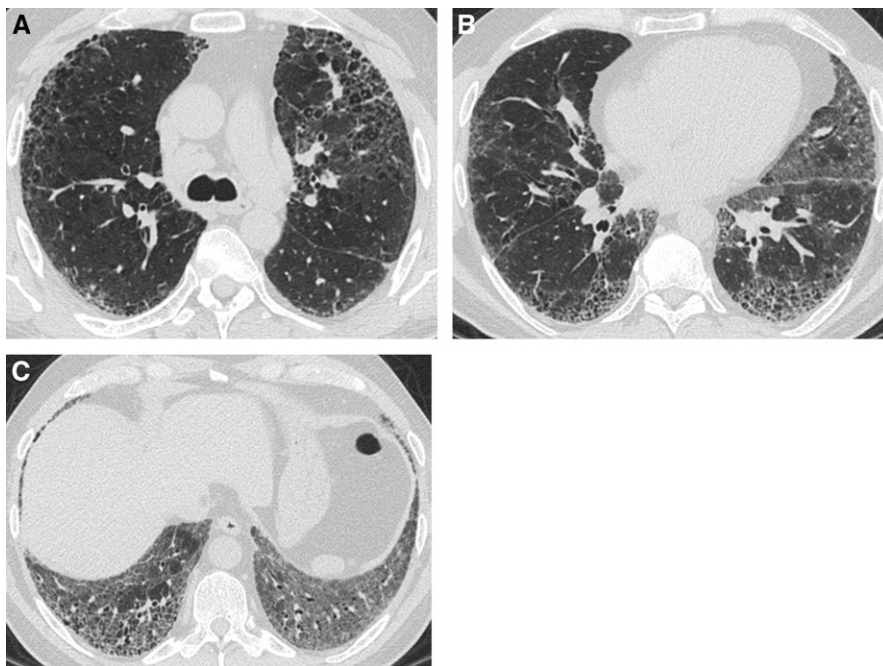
Indeterminate pattern. (A–C) Transverse computed tomography sections showing extensive lung infiltration combining honeycombing, mild to marked ground-glass opacity, asymmetrical distribution between both lungs, and no subpleural predominance.
